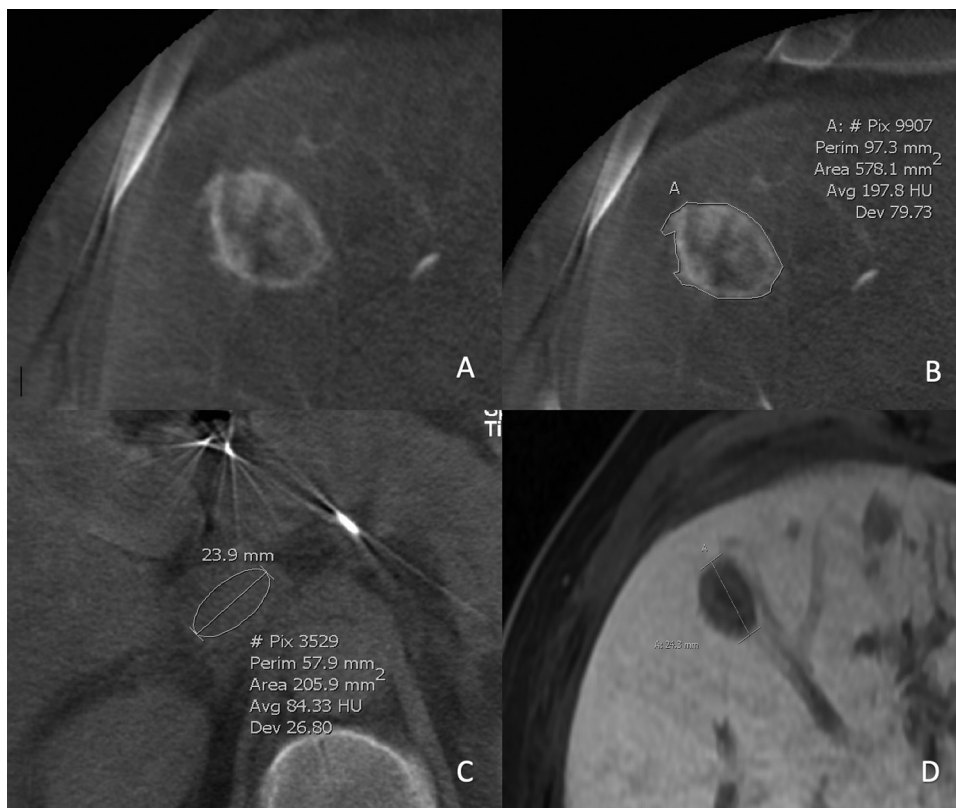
Images of a 56-year-old patient with liver metastases of a neuroendocrine tumor of the small intestine. A: CBCT during diagnostic workup for TARE showing a contrast enhancing liver metastasis of the right lobe. B: A 2D ROI is manually drawn around the lesion. Lesion enhancement of 197.8 Hounsfield units (HU) is noted. C: For relative enhancement calculation, a ROI is also drawn in the inferior vena cava. This shows 84.33 HU, making a relative lesion enhancement of 113.47 HU. D: Length of the metastasis is measured on a follow up MRI scan 6 months and 20 days after TARE. For this patient, a diameter reduction of 24.45% was found for the sum of all lesions, which was classified as partial response (PR) according to the RECIST 1.1 criteria.
